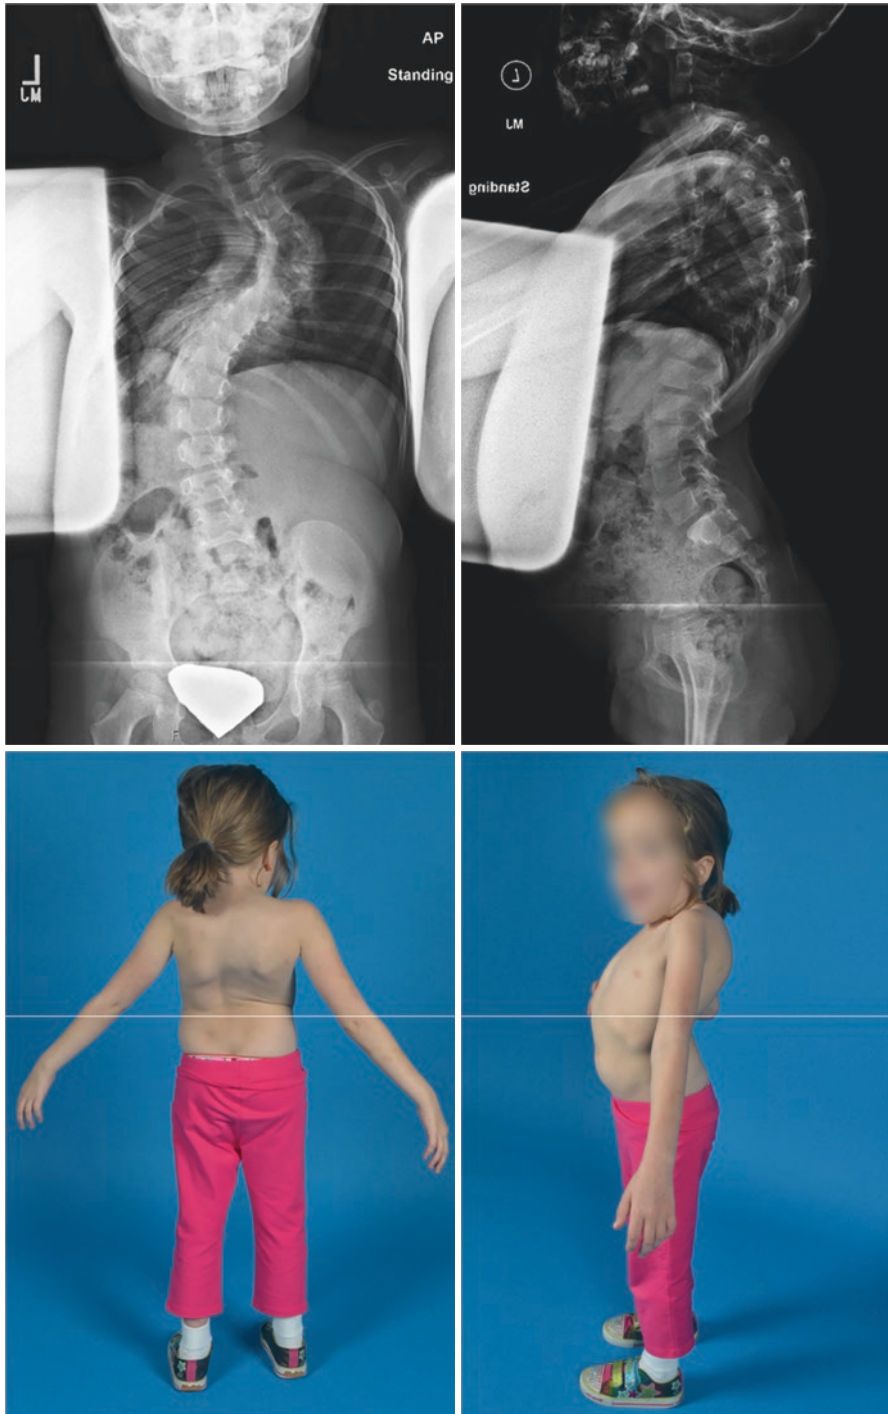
Clinical and radiographic representation of scoliosis associated with neurofibromatosis. Radiographically the curve is short, sharp and kyphotic. Clinically note the café au lait spots
